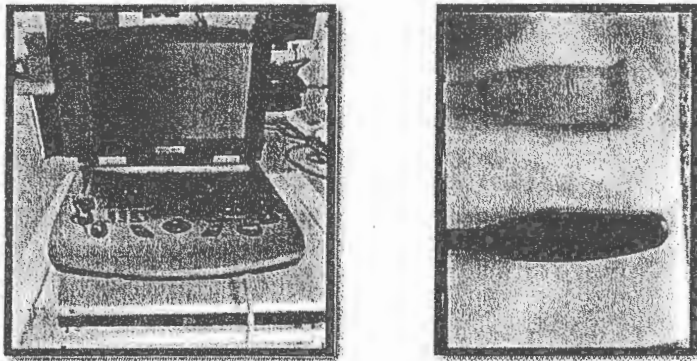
An ultrasound machine (EXAGYN ECM company, France) (the left). A micro convex probe 3.5-5 MHz and a linear array probe 6-8 MHz (the right).
